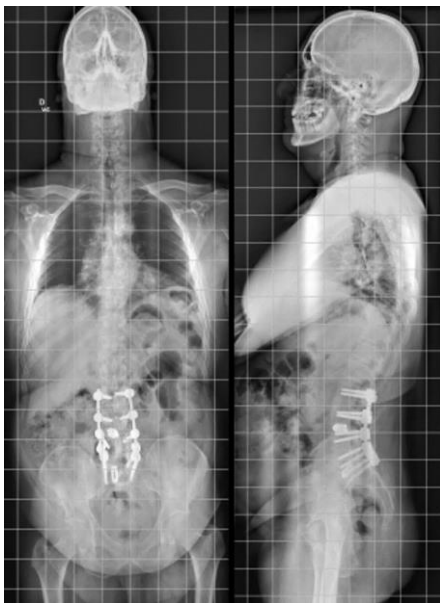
A-B. Preoperative (EOS) X-ray showing sagittal imbalance and previous instrumentation L2-S1 and two interbody
